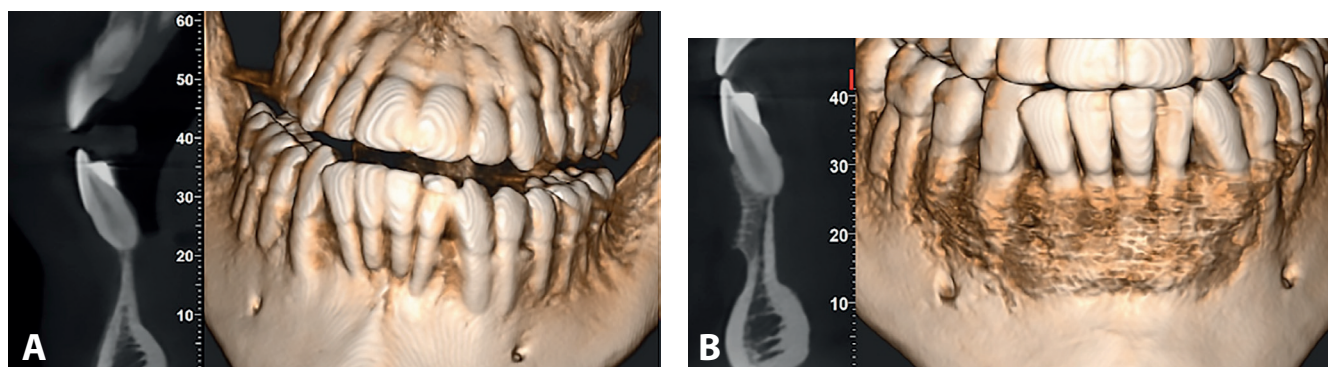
Cone beam computed tomography (CBCT) scans before (A) and 6 months after bone reconstruction (B) – example patient No. 1
